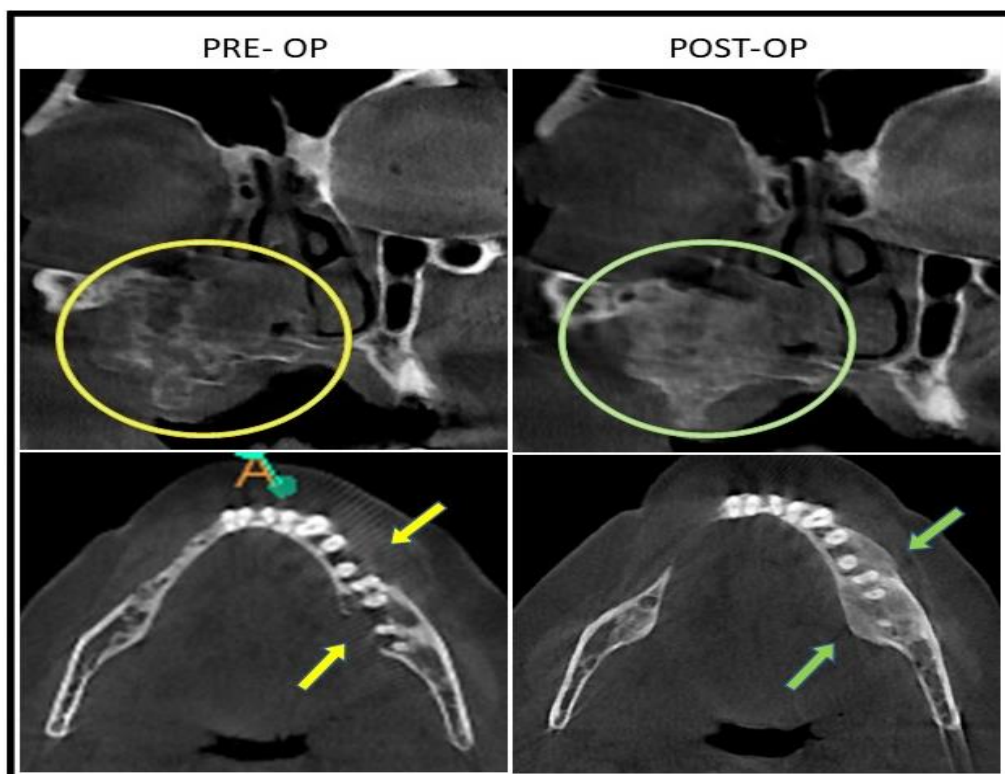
(a) pre-op radiograph (yellow) (b) 3 months post-op radiograph reveals slight regression of lesion with an increase in bone density due to disordered mineralization pattern (green)
